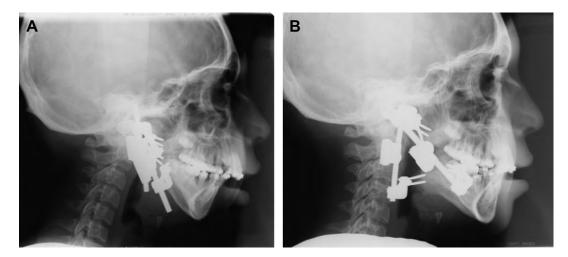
Lateral radiographs of the patient in Fig. 11. (A) The predistraction radiograph shows the devices are approximately parallel. (B) During distraction premature consolidation occurs on the left. The distraction devices lose parallelism as osteogenesis ceases on the left side.
